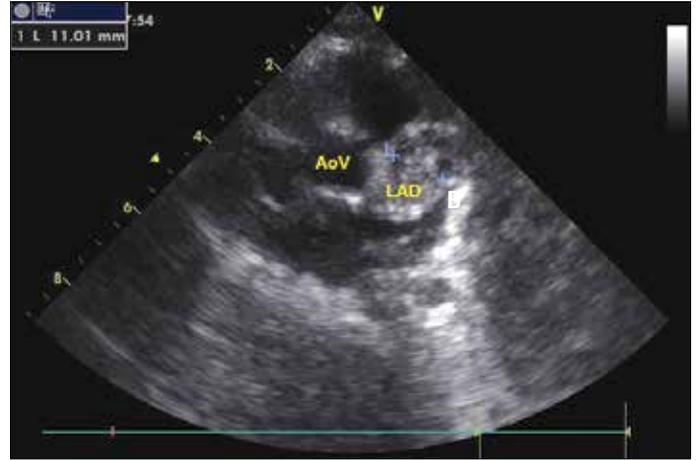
Echocardiography showing a thrombus obstructed the lumen in LAD
